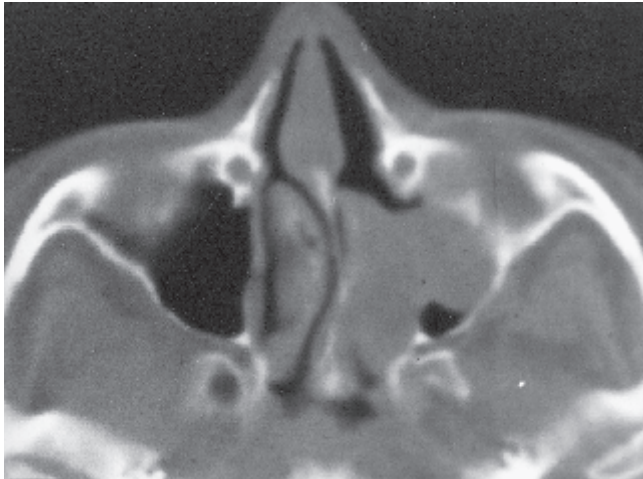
Axial CT-scan from a 54-year-old female patient demonstrates recurrence of ACP after previous surgery. The root of the ACP is attached to the lateral wall of the sinus. The polyp protrudes into the nasal cavity through the widely opened naso-antral window.
